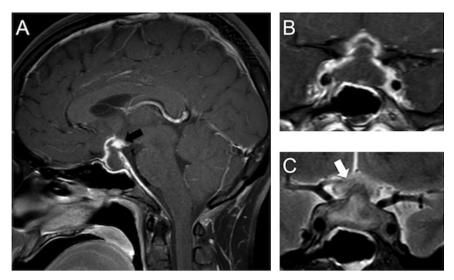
(A) Sagittal and (B) coronal postcontrast T1-weighted images shows rim enhancing hypointense T1 lesion in the sellar and suprasellar region with thickened enhancement of the pituitary stalk (black arrow) and additional meningeal enhancement along sellar floor an clival area. (C) Coronal T2-weighted image demonstrates compression of the optic chiasm (white arrow) by this lesion with hyperintense T2 change, representing optic neuropathy.
